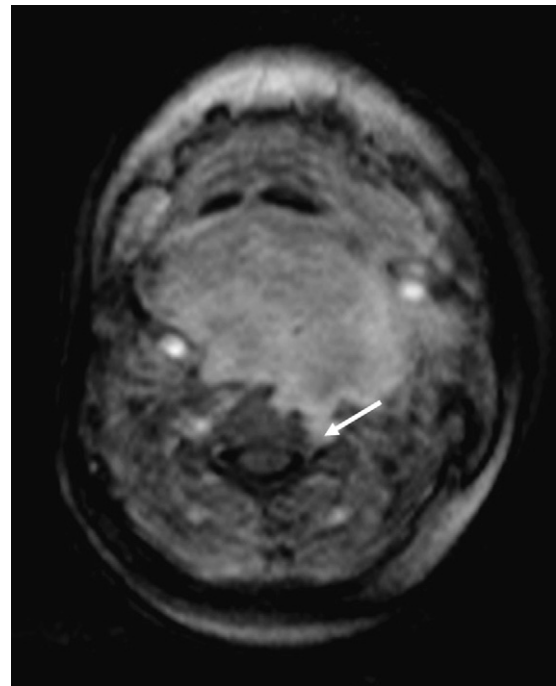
Contrasted axial MRI of the neck shows the mass enhances heterogeneously with no evidence of extension into the spinal canal (arrow). There is infiltration of the mass into the left anterolateral aspect of the vertebral body. High signal changes were also noted in the adjacent left sternocleidomastoid muscle.
